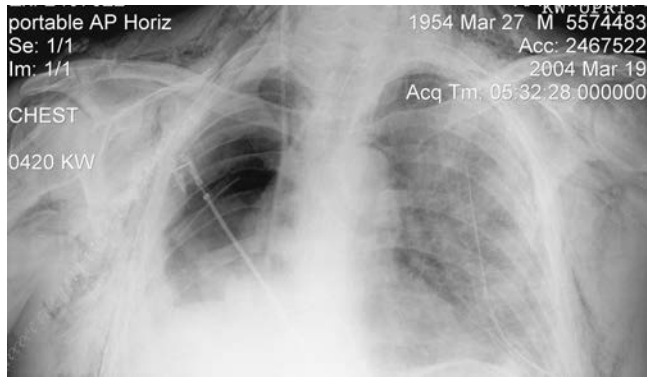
• In the patient's postoperative day 3 chest x-ray, note the pulmonary edema pattern in the left lung and the normal cardiac silhouette, suggesting an acute lung injury pattern.
